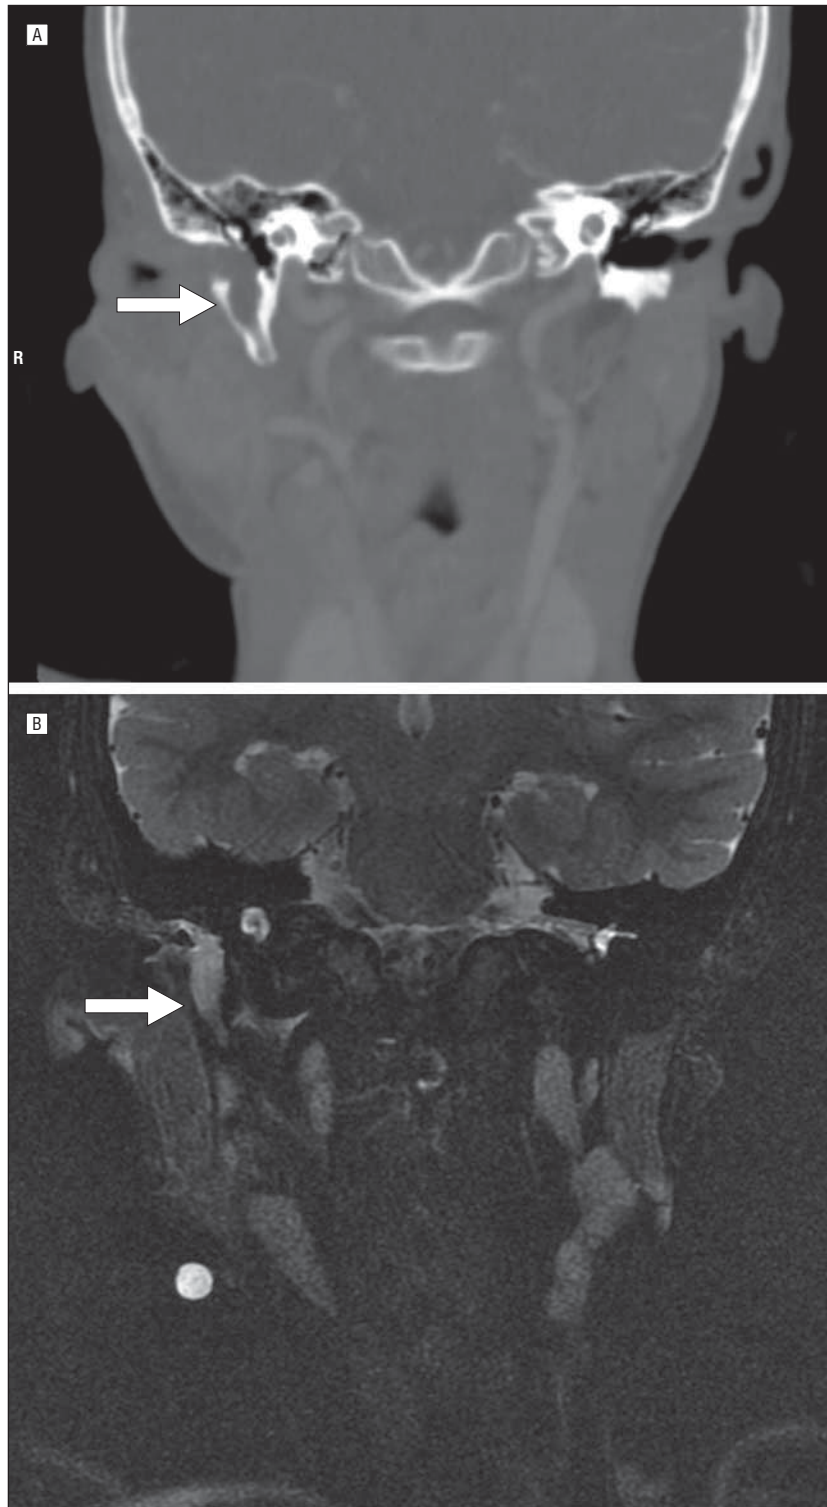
Case 2. A postcontrast coronal computed tomogram showing a dysmorphic styloid process and bony ear canal defect (A, arrow) and a T2-weighted fat-suppressed magnetic resonance image showing a fistulous tract (B, arrow).
